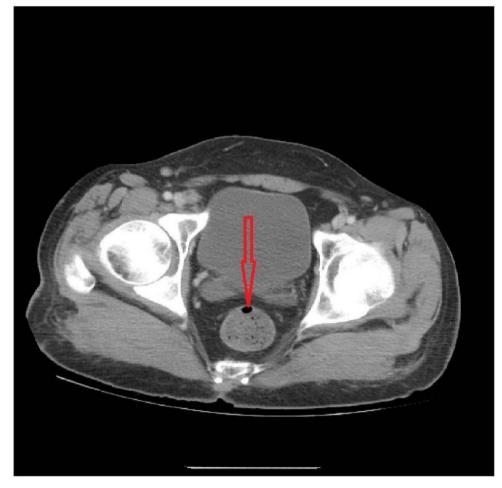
CT scan of pelvis shows thickening of the rectum.
